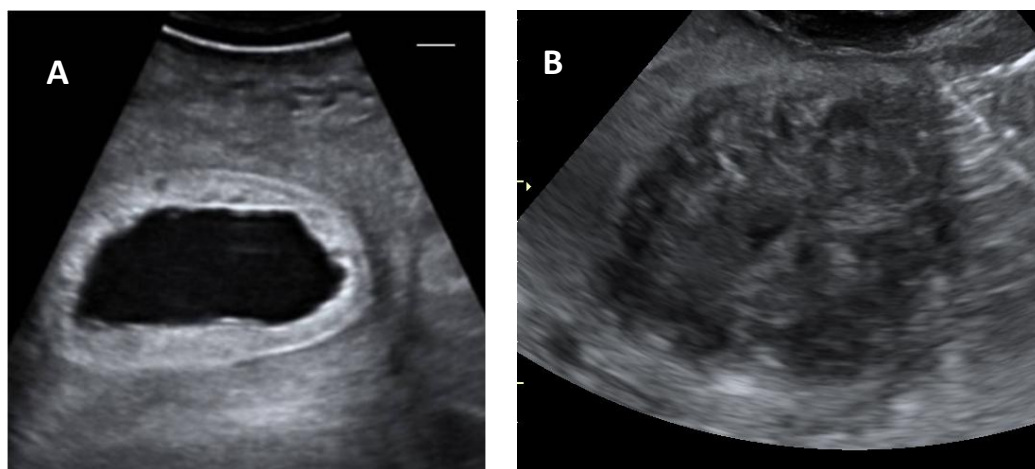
Examples for pathological uterine findings during ultrasound in female Asian elephants: A. Pyometra: fluid content in uterine horn (black) and inflamed endometrium (white) → vaccination would be detrimental! This condition needs treatment before GnRH vaccination may be considered; B. Leiomyoma in uterine horn destroyed normal appearance at this stage, no distinction of myometrium and endometrium possible anymore → GnRH vaccination may prevent further growth and damage.
